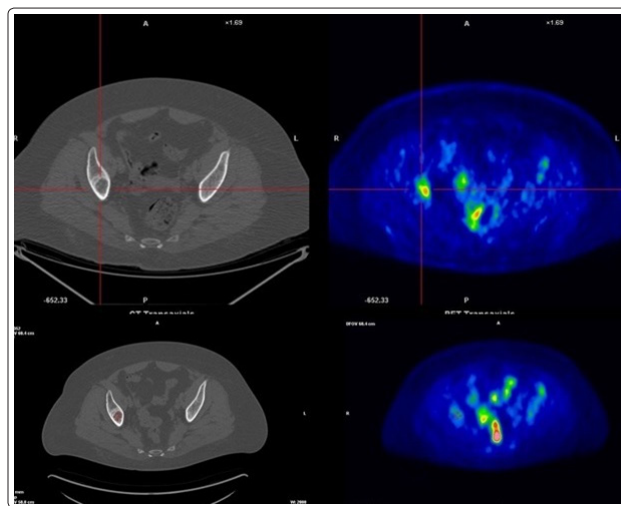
Comparison of the two FDG PET-TC scans (January 2017 and October 2017) shows no metabolic activity due to the current treatment
